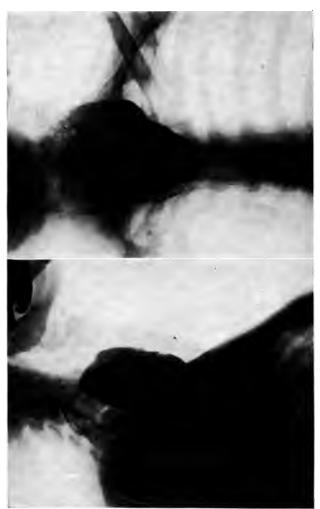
Differential diagnosis of intrathoracic goiter. Radiograph of esophageal diverticulum.
